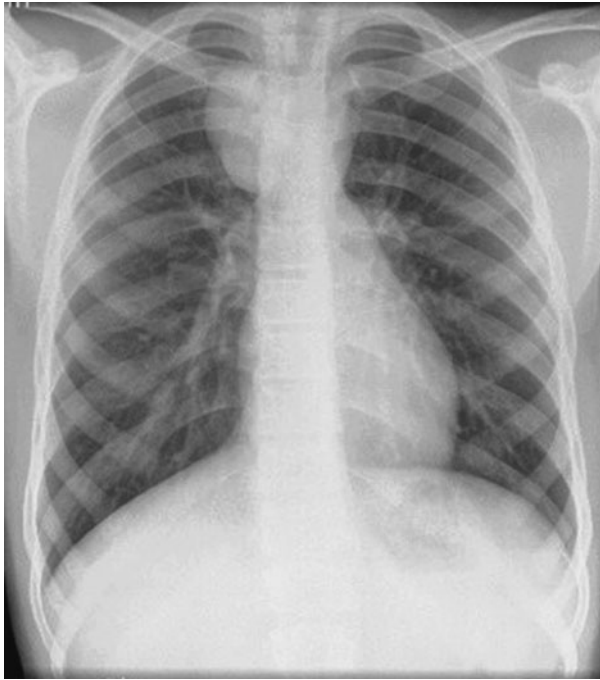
Incidental chest x-ray finding of a duplication cyst in a previously asymptomatic patient. This x-ray was done for blunt chest trauma. Subsequent investigation confirmed this to be an esophageal duplication.
